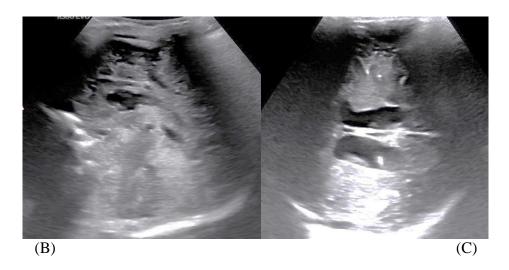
Preterm newborn male with HIE grade-III scanned at >72 hours. (A), (B) and (C) Coronal, axial and sagittal view of cranial ultrasound showing extensive periventricular cysts seen in frontoparietal region (PVL Grade-III)
